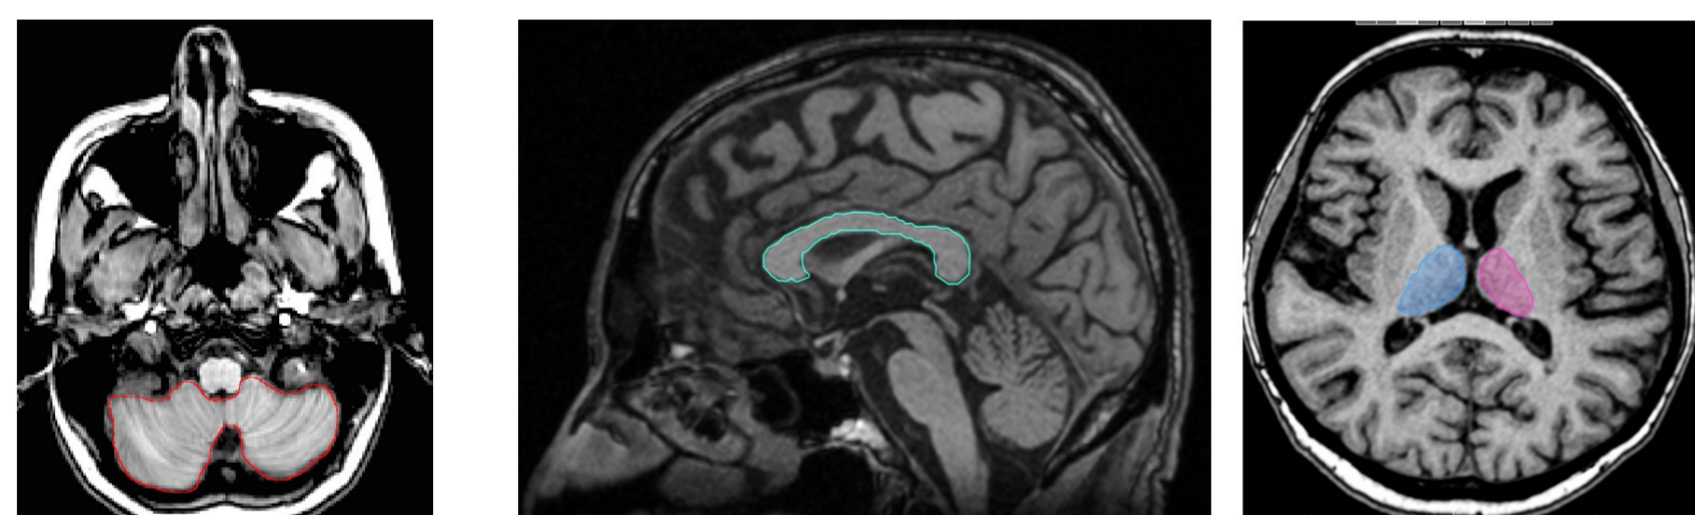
Examples of brain MRI measurements – volumes of cerebellum, corpus callosum, thalami.
